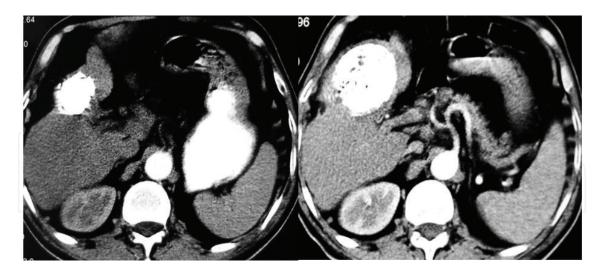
Left: Triphasic CT scan revealed enhancing right lobe focal lesion in the arterial phase. Right: Post TACE triphasic CT scan obtained 1 month showed complete cure.
